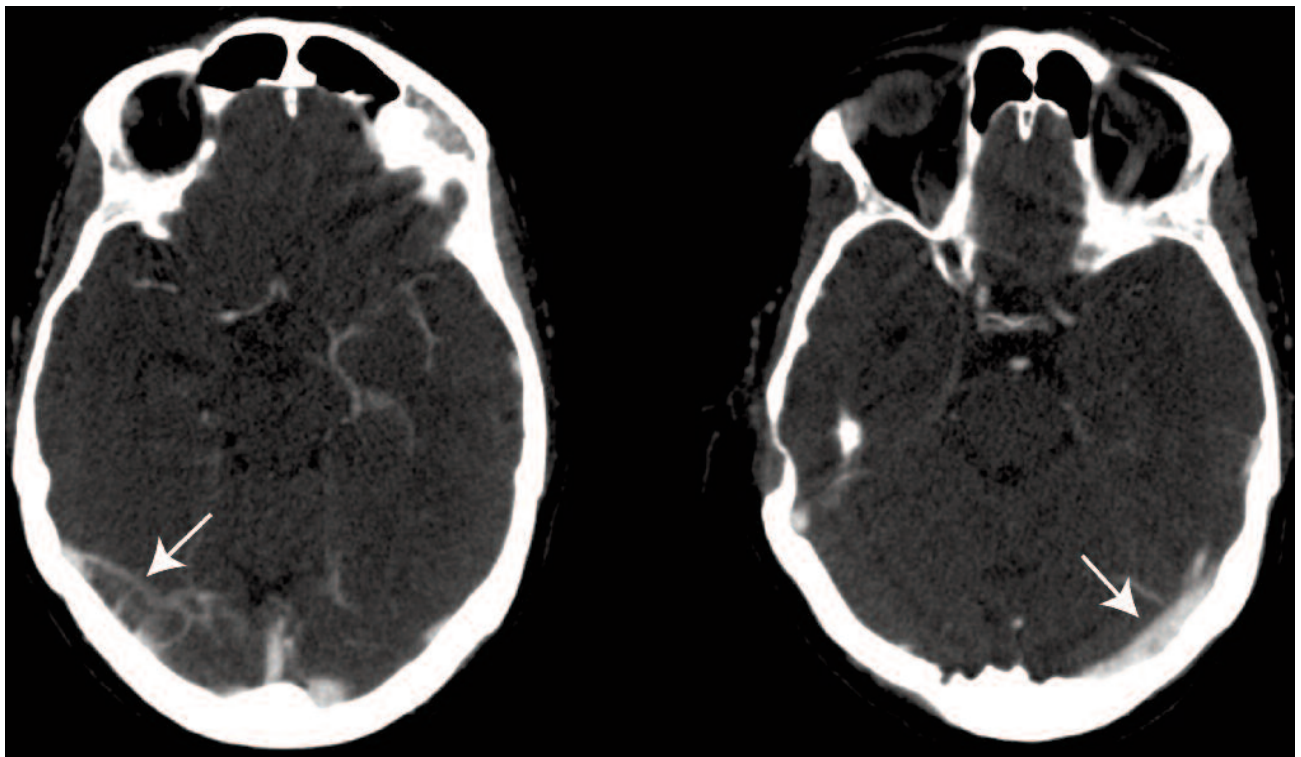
CT scan (August 2007) with contrast in the axial plane showing a thrombosis of the transverse sinus on the right site. Arrows indicate the position of the transverse sinus, no flow is visible on the right side.
